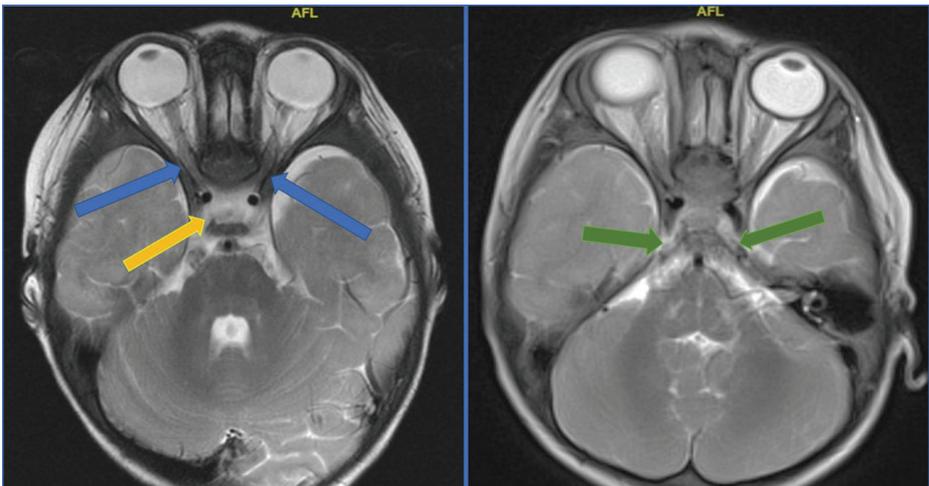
A contrasted brain MRI at orbital cut (T2-weighted axial view) showing the bilateral optic nerve (*blue arrow*), chiasm, (*yellow arrow*) and optic tract are oedematous and swollen. Both optic tracts are hyperintense (*green arrow*).
